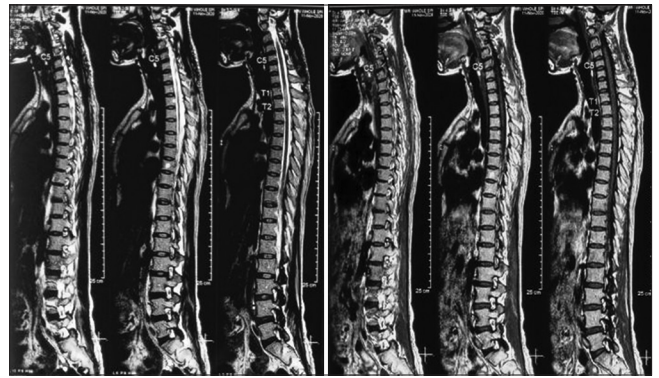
MRI Whole Spine with IV contrast. A round hyperintense lesion is seen on the Th8 vertebral body
